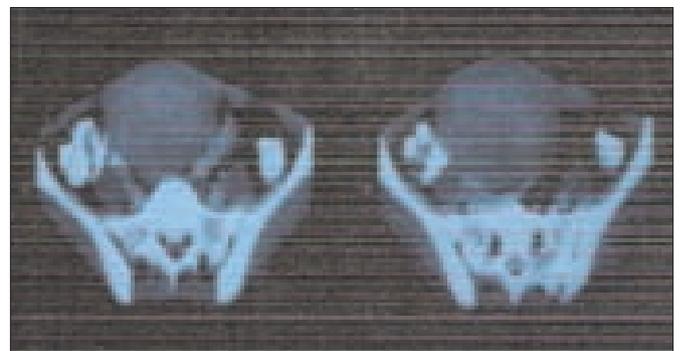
CT scan abdomen and pelvis with contrast enhancement demonstrates the desmoid tumour infiltrating the anterior abdominal wall.
